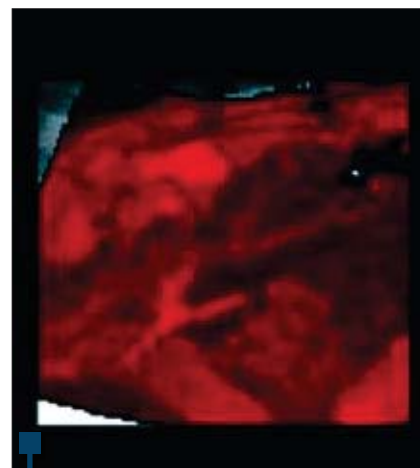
3D and power Doppler ultrasound - placenta
